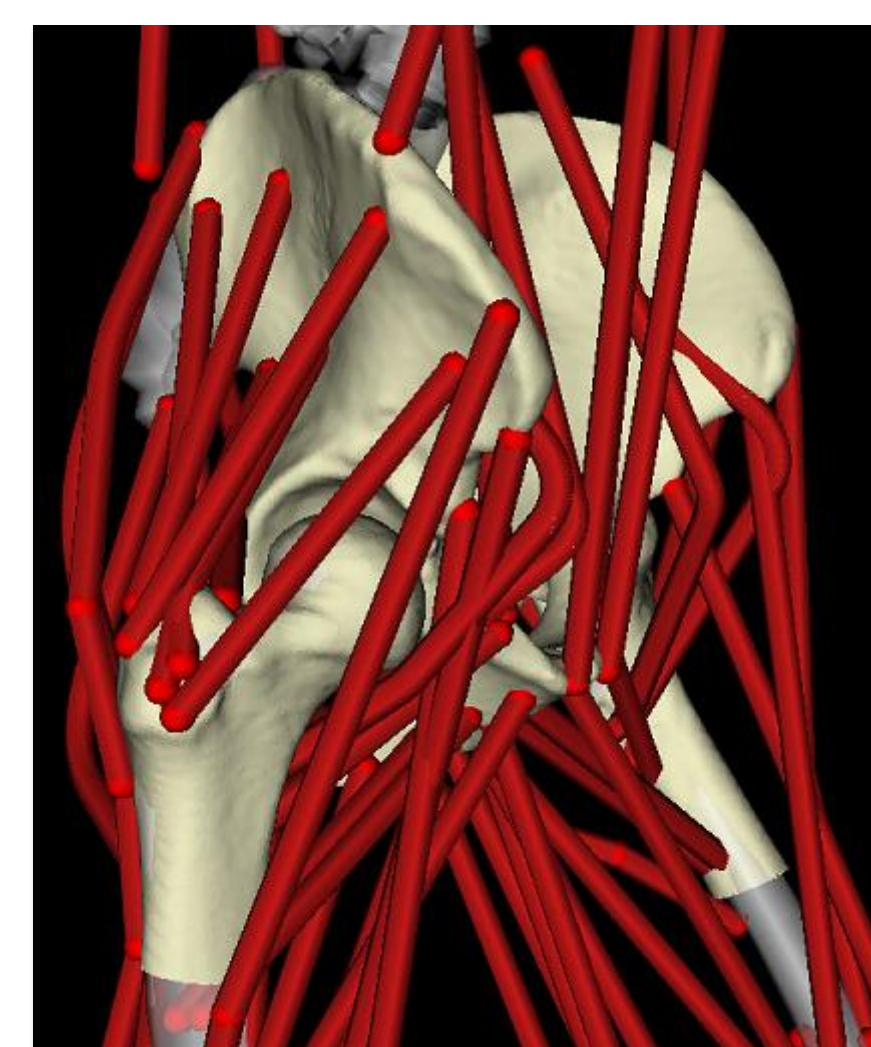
Subject-specific MSM with CT-based hip anatomy, updated muscle paths and HJC locations.
